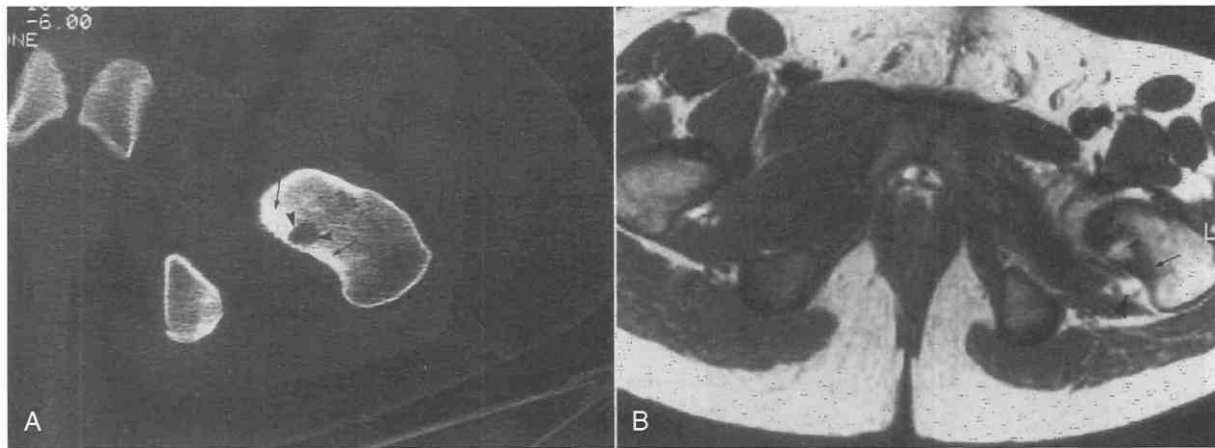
Intra-articular osteoid osteoma in a 16-year-old boy with hip and knee pain. *A*, CT scan shows a focal low-attenuation nidus (small arrowheads) in the endosteal region of the femoral neck medially with mild associated reactive sclerosis (arrows). *B*, Proton-density axial MR image reveals osteoid osteoma nidus of intermediate intensity (small arrowheads) with reactive sclerosis showing low signal intensity (arrows). Reactive joint effusion resulting from lymphofollicular synovitis is also seen (large arrowheads).
